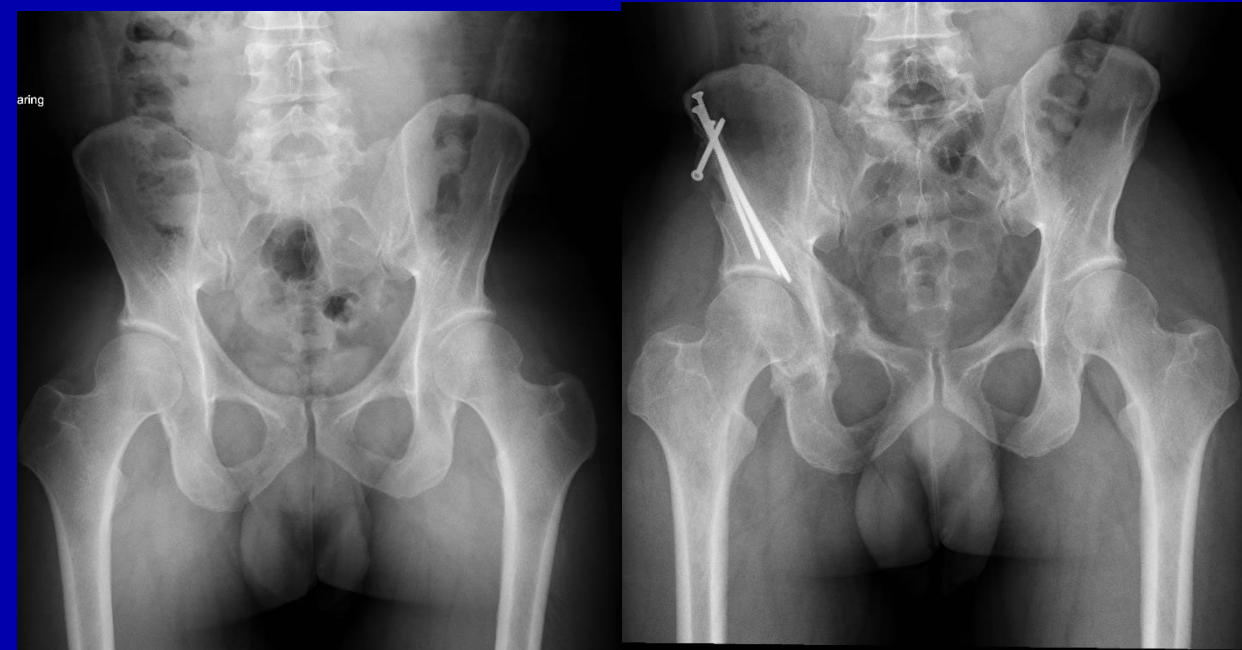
Pre- and post-operative AP pelvis radiographs of a 35M with right hip dysplasia treated with PAO
